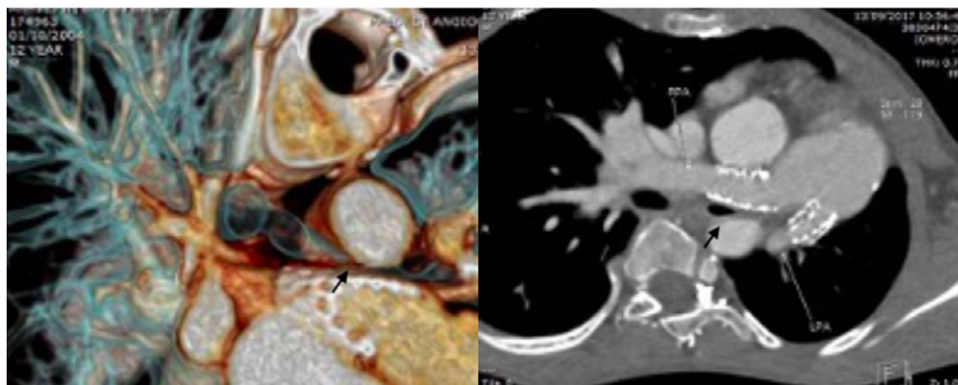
CT scan belonged to 12-year-old boy who developed significant bilateral proximal PA branches stenosis following truncus repair that required stenting. His CT shows compression of the left bronchus (arrow) from the stented proximal right pulmonary artery. The left lung was hypoplastic with compensatory hyperinflation of the right lung.
